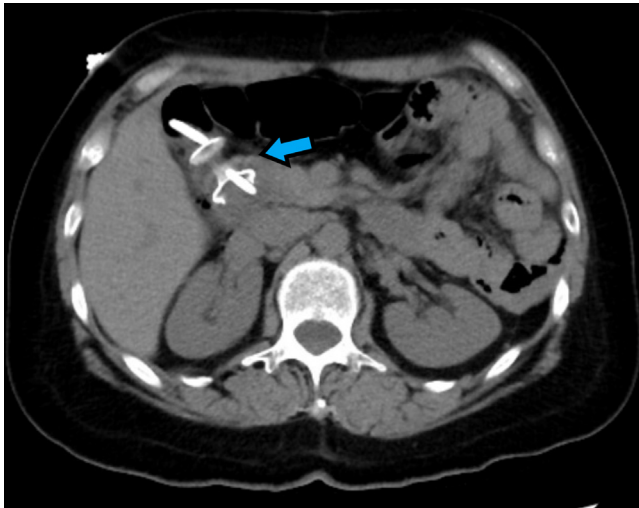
AXIOS (Boston Scientific, Marlborough, Mass, USA) and double-pigtailed stent appearance on a CT scan (axial image).
